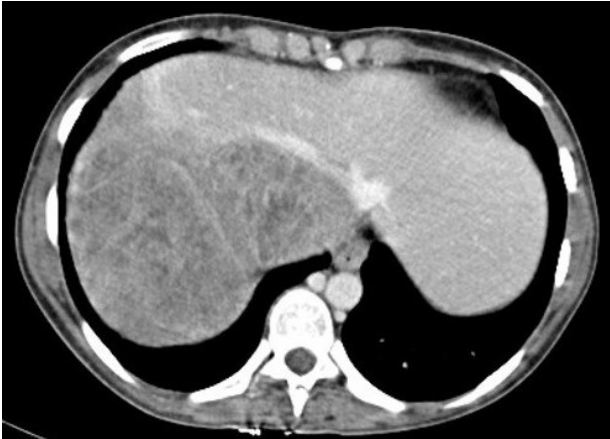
CT scan, axial plane. The mass compresses and displaces the right hepatic lobe and IVC.
